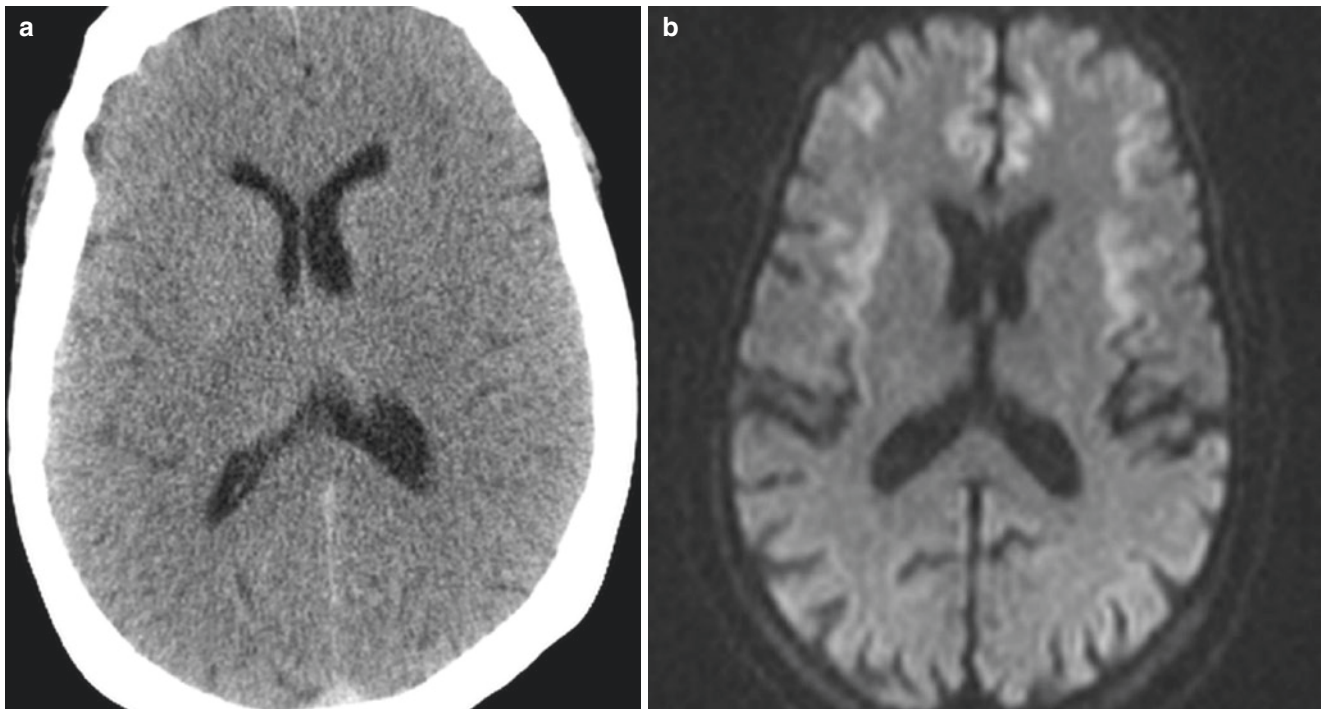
Hyperammonemic encephalopathy. (a), Patient with liver failure and altered mental status. NCCT shows diffuse cerebral edema, sulcal effacement, and loss of gray–white differentiation. (b), DWI MRI
